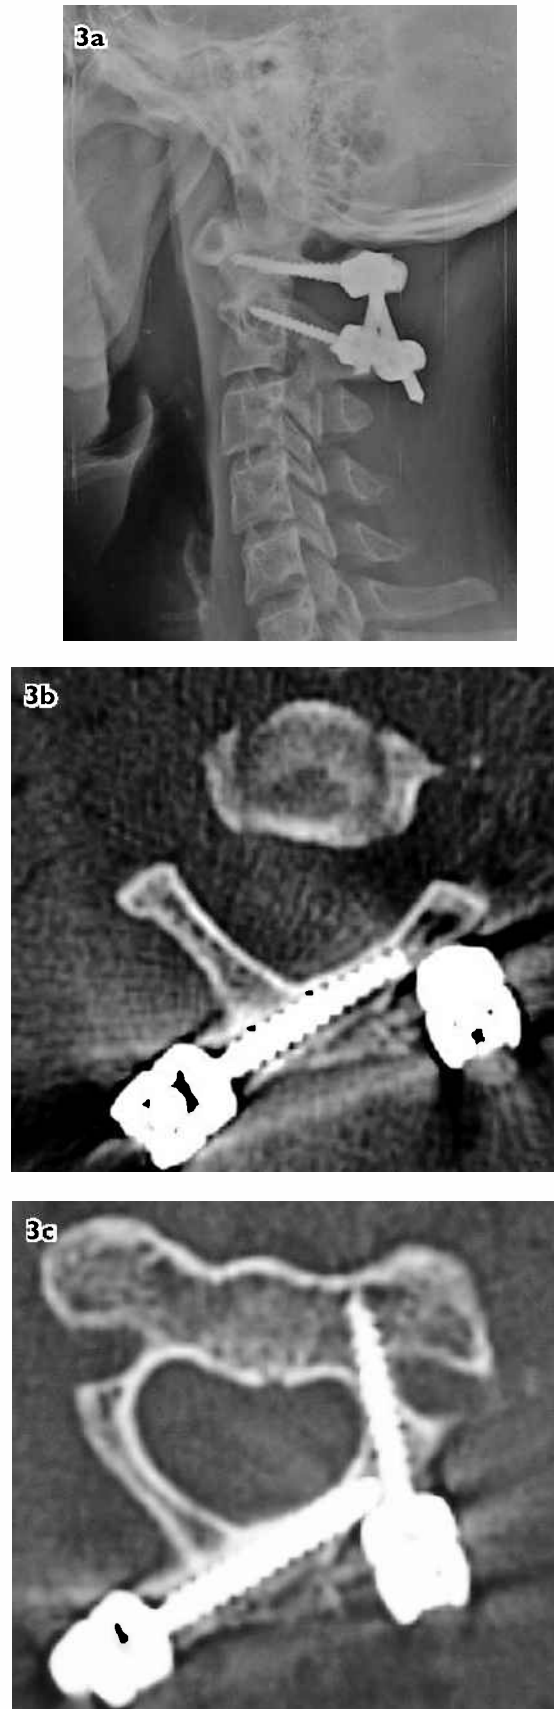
Postoperative (a) radiograph and (b & c) CT images show accurate placement of the C2 translaminar and pedicle screws.
